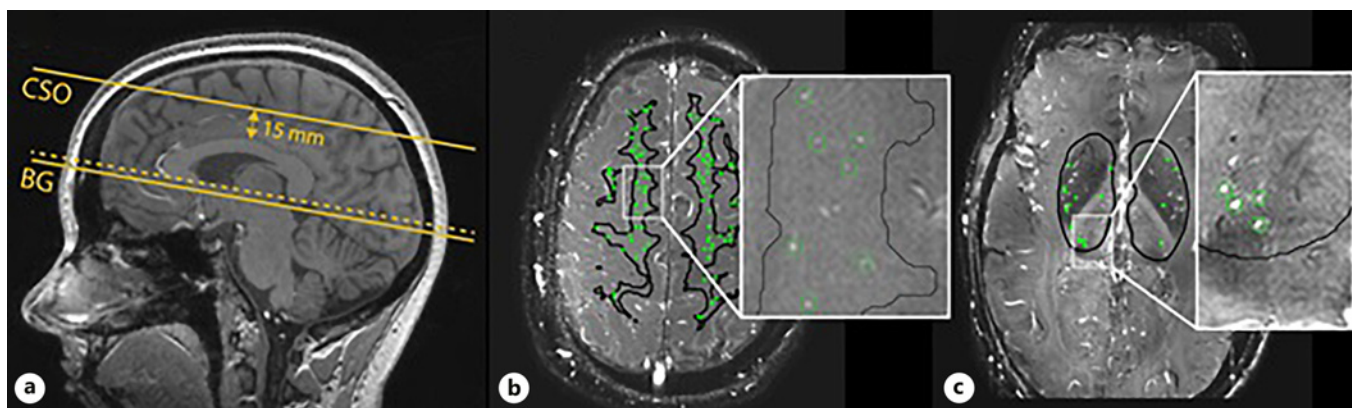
Planning of the two-dimensional (2D) quantitative flow (Qflow) slices and regions of interest (ROIs). a Planning of the BG and CSO slices on a sagittal T1-weighted image. The slice planning is indicated by the yellow lines. For the BG, a 2D slice is planned through the anterior commissure, parallel to the genu aligned to the splenium of the corpus callosum (dotted line) and aligned in the horizontal plane for the left/right axis; CSO planning is parallel
